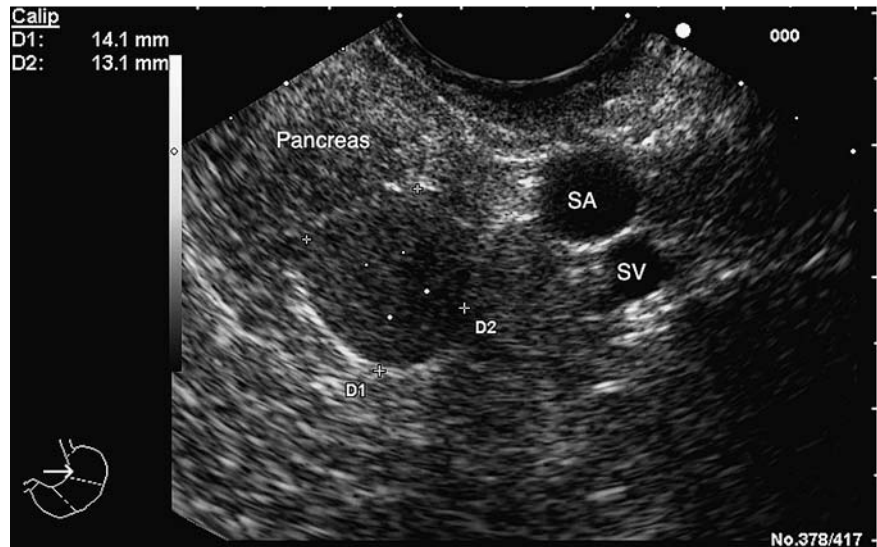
Endoscopic ultrasound shows an oval, well-defined, isoechogenic, homogeneous, 14-mm mass located in the pancreatic tail. There is no cystic component or calcification (SA, splenic artery; SV, splenic vein).
